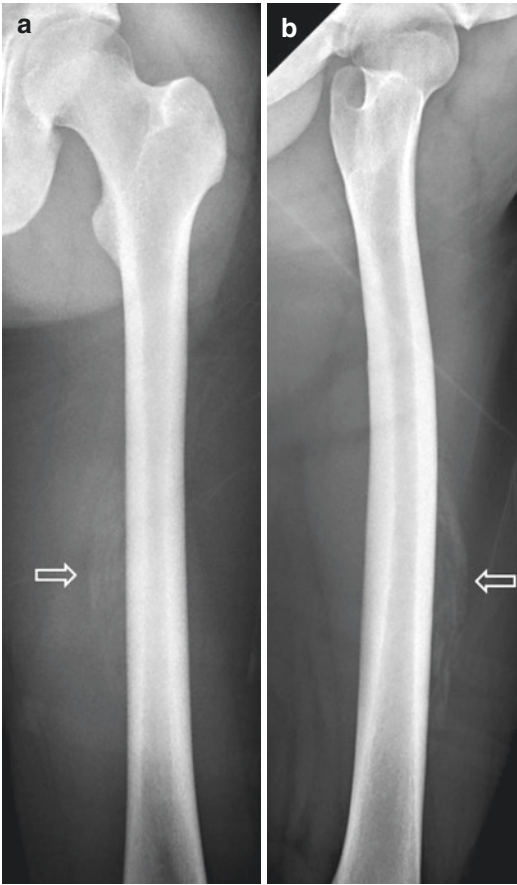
A 17-year-old man who had a history of trauma to the left thigh 2 weeks before presentation. (a) Frontal and (b) lateral radiographs of the left femur show faint curvilinear sheet-like calcifications (*arrows*) adjacent to the mid-shaft of the femur. In the context of recent trauma, this appearance is highly suggestive of myositis ossificans. Note the external artifacts due to the patient's clothing
